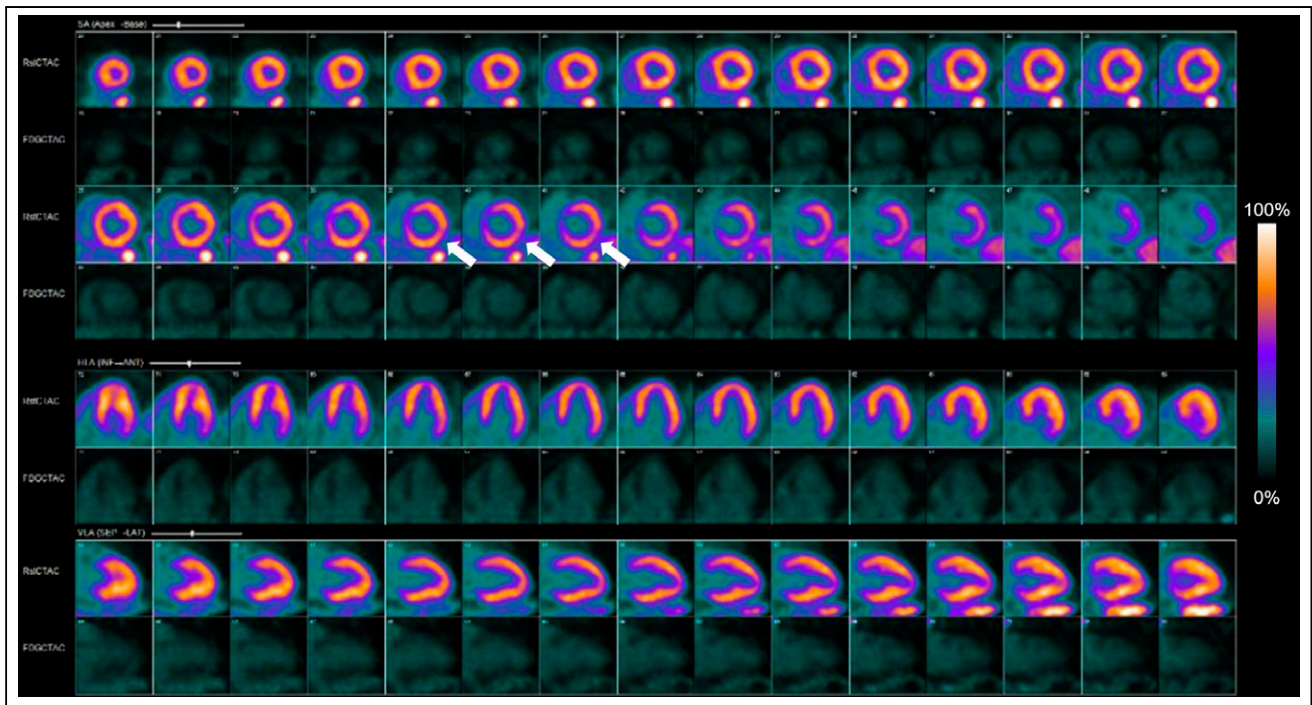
Scan 1 ^{82}Rb -chloride rest perfusion (top rows) and ^{18}F -FDG cardiac metabolism (bottom rows). Rest perfusion images show small mid inferolateral wall defect (white arrows) and normal distribution of activity throughout remaining LV myocardium. Gated rest LVEF is 32%. ^{18}F -FDG cardiac slices show suboptimal display intensity for ^{18}F -FDG cardiac sarcoidosis imaging, as neither ^{18}F -FDG myocardial blood-pool activity nor activity in LV myocardial wall can be appreciated in current display.
